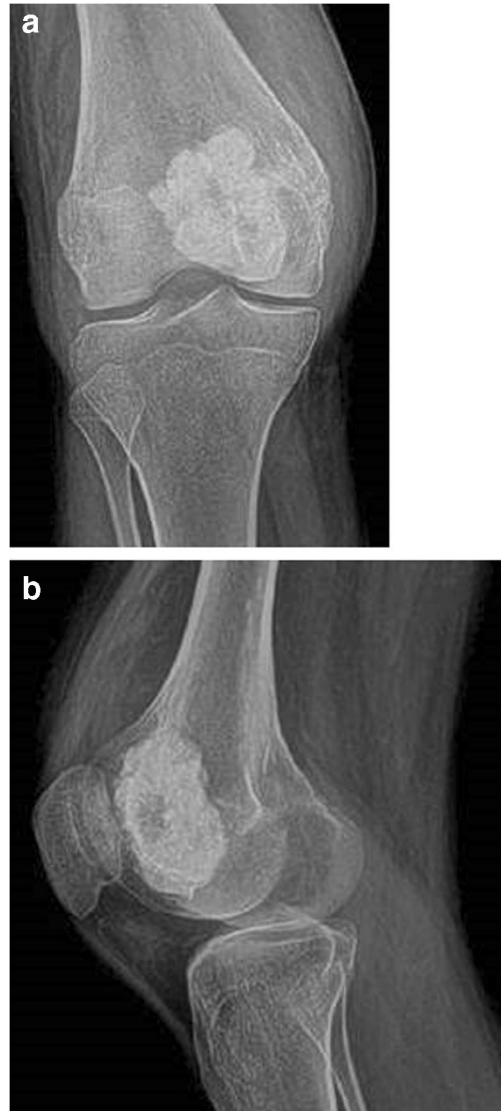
a AP and b Lateral radiographs of the right knee
